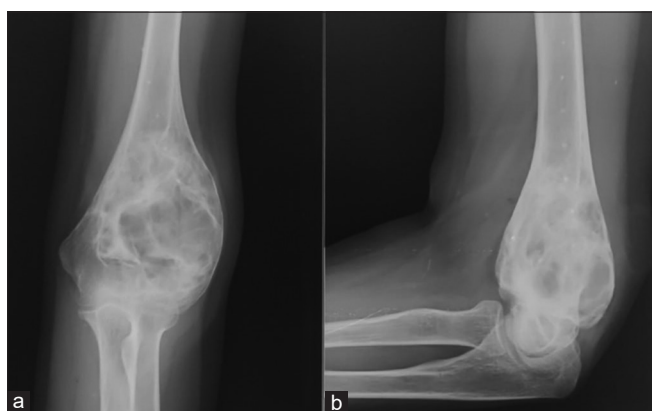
Follow-up radiograph taken 1 month post 1<sup>st</sup> sclerosant injection
